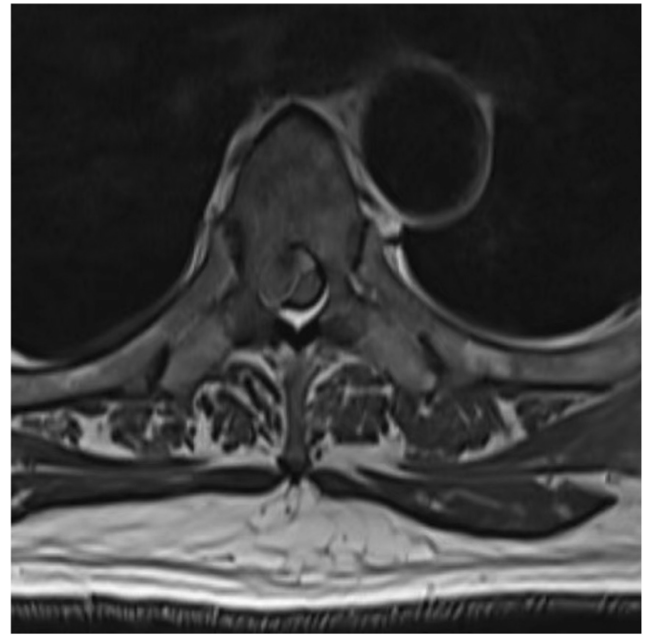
Axial T2-weighted sequence showed mixed signal.
